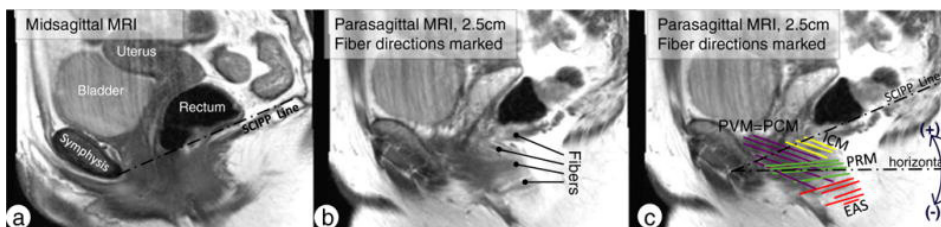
a Midsagittal MRI view of the muscles from the left side of the pelvis. The sacrococcygeal inferior pubic point (SCIPP) line is drawn in the midsagittal plane and transposed to all parasagittal slides. b Fibers are demonstrated (lines with round tips) on a parasagittal slide. c Fiber directions were marked and evaluated in respect of the individual SCIPP line and expressed as the angle to the average horizontal line. PVM pubovisceral muscle, PCM pubococcygeal muscle, ICM iliococcygeus muscle, PRM puborectalis muscle, EAS external anal sphincter muscle⁷
